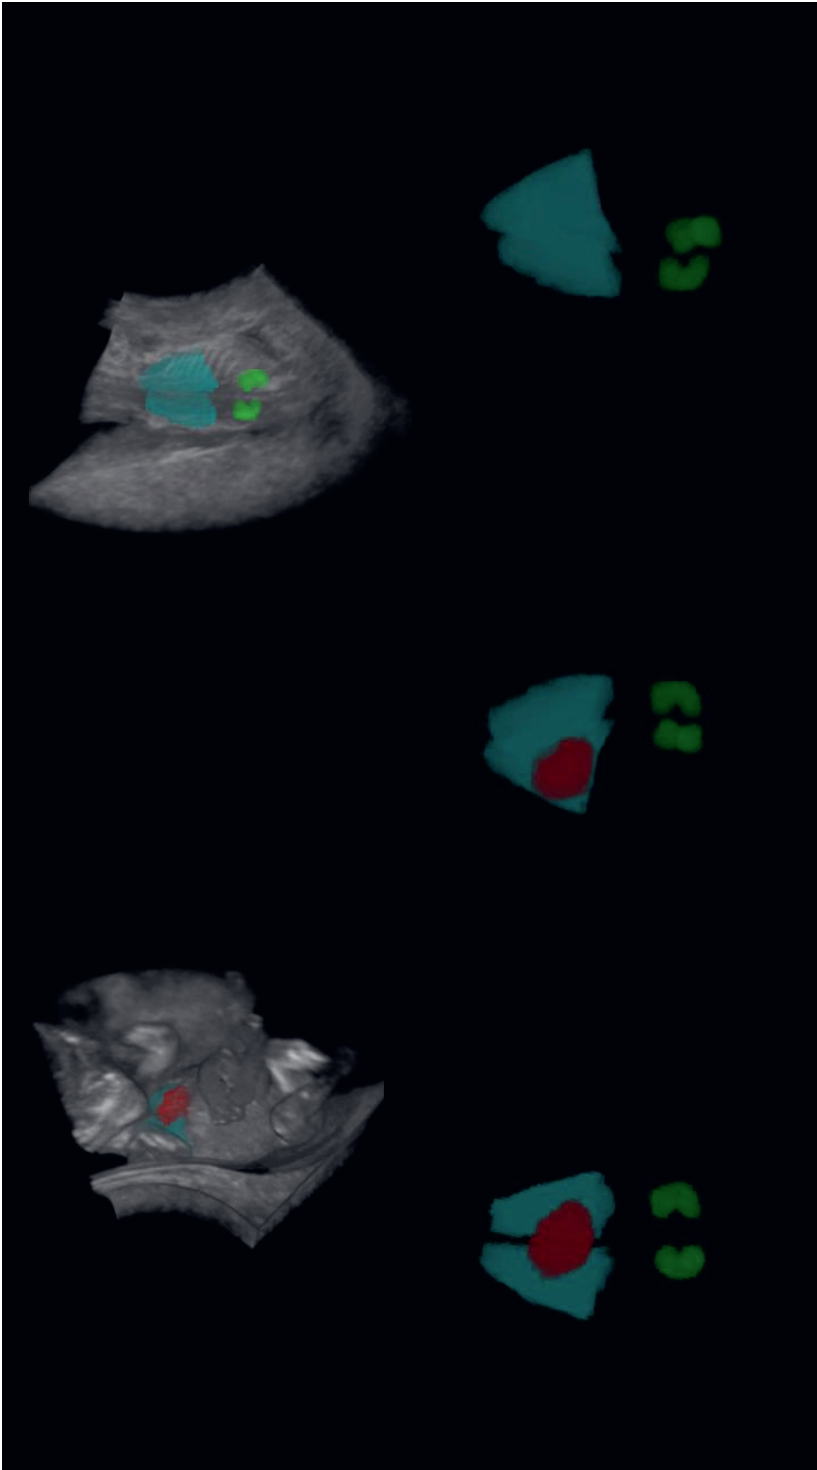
Three-dimensional view of the segmented heart (red), lungs (cyan) and kidneys (green) of a fetus at 11 weeks and 6 days of gestation in the BARCO I-Space obtained using the V-scope application. Upper row of images show the segmented organs within the 3D ultrasound dataset, left is anterior view and right is posterior view. Lower row of images show the segmented organs (supporting video file is provided as supplementary video S1).
